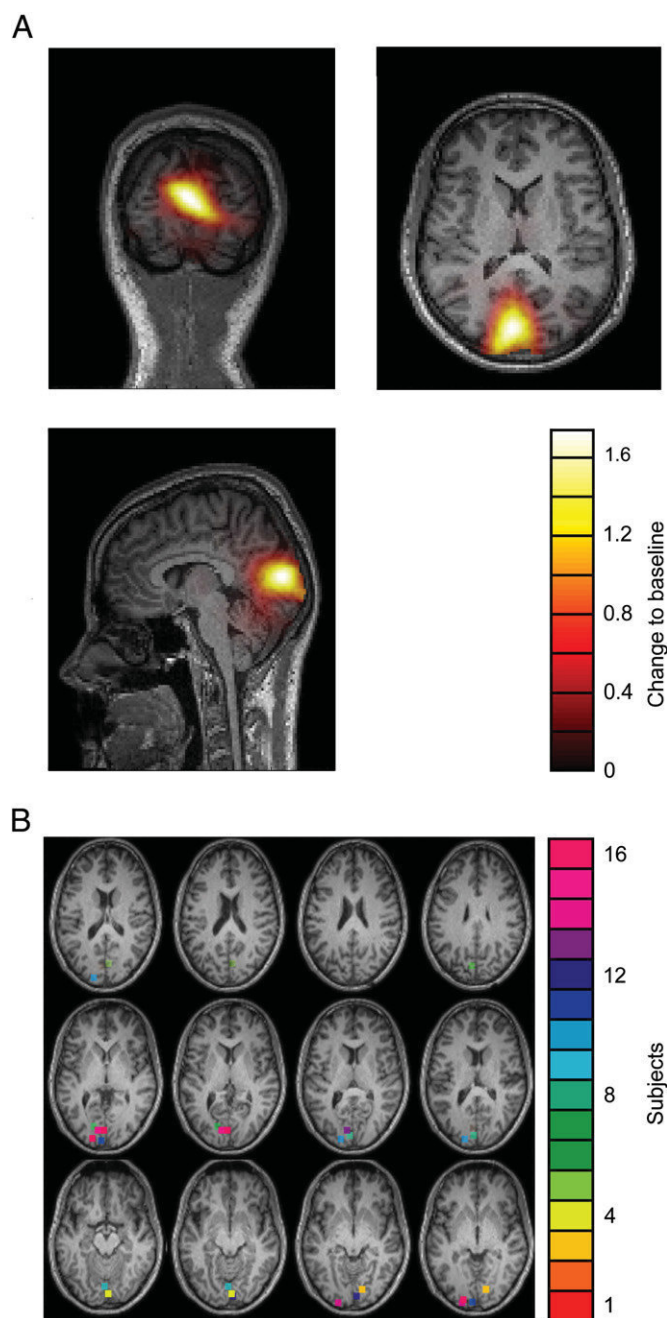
Localization of gamma band power. A. Gamma band power relative to pre-stimulus baseline activity was localized in early visual areas. Displayed here is the grand average over all correct trials of all conditions for one representative subject (Subject 2). Colors indicate intensity of relative change to the pre-stimulus baseline. Values below 0.5 are masked. B. Virtual sensors were localized in areas V1 and V2 in 14 of 16 subjects. Shown here are virtual sensor locations for all subjects displayed on one individual brain normalized to a smoothed template MRI based on multiple subjects (Statistical Parametric Mapping; SPM2; <http://www.fil.ion.ucl.ac.uk/spm/>). Each colored point represents the virtual sensor of one subject. Please note that for visualization purposes, the kernels of the virtual sensors were extended to 9 mm. Slice thickness was 3 mm. For that reason, some virtual sensors are present in multiple slices.
